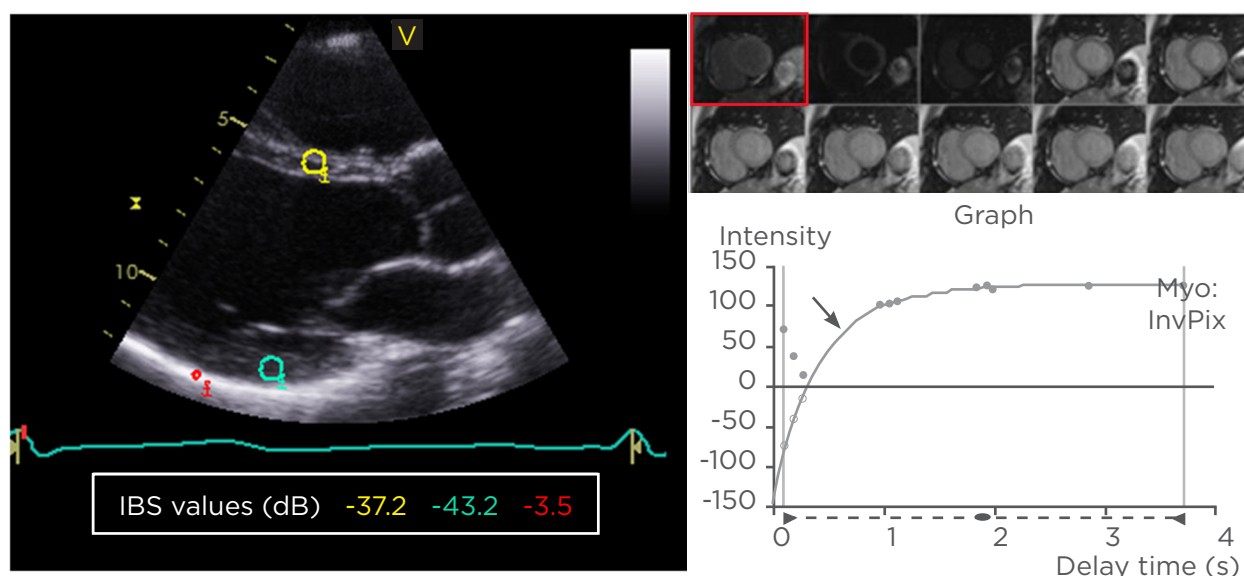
Echocardiographic quantification of myocardial fibrosis.
